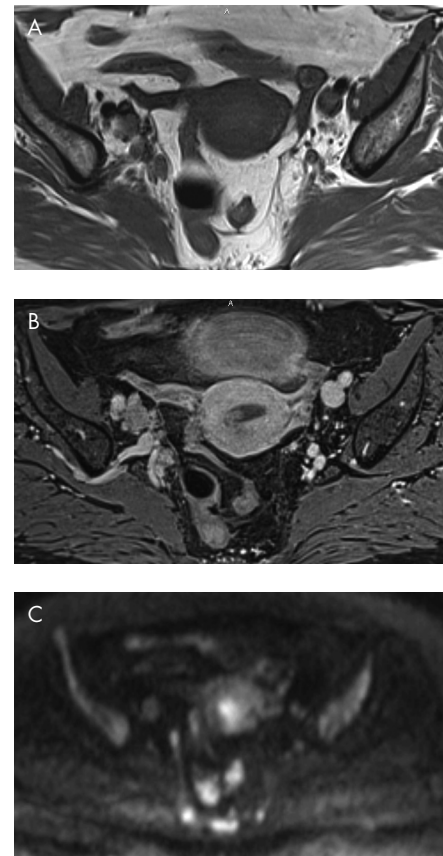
a,b,c. Pelvic MR study of an endometrial cancer patient. T1 pre-contrast (a) and post-contrast (b) images show an enlarged pathologic right obturator lymph node. Diffusion-Weighted Image (DWI) acquired with a 900 b-value (c) shows hyper-intensity of the lymph node due to low water-motion of molecules, thus confirming its positivity
